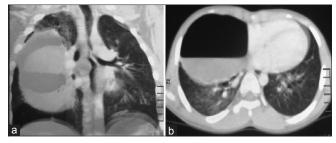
(a) Computed tomography thorax showing well-defined cyst in right hemithorax. (b) Computed tomography thorax showing air-fluid level in cyst
